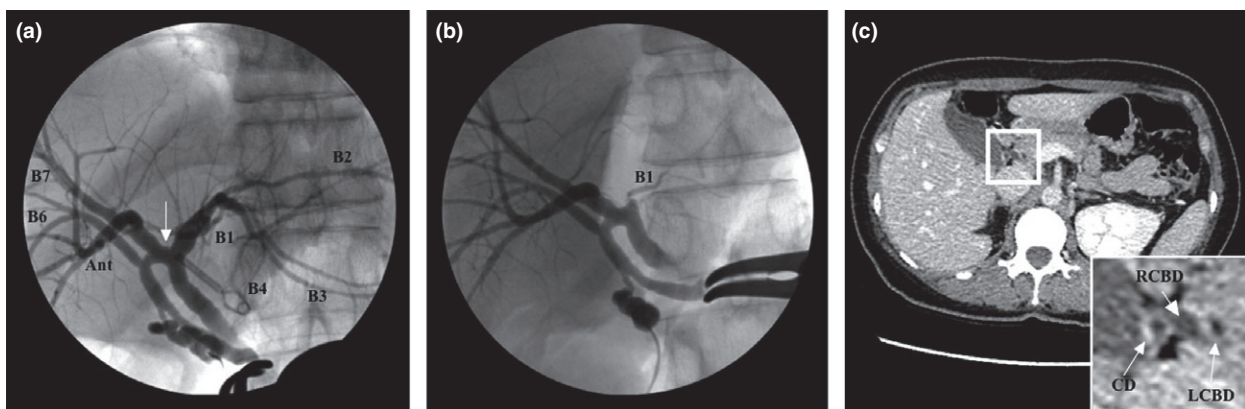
(a) An IOC image showing the single biliary drainage of DCBD with a proximal communicating channel (white arrow). The cystic bile duct is fused with the right common bile duct. (b) An IOC image demonstrating an optimal site of biliary transection (white arrow). (c) Preoperative computed tomography showing the cystic duct (CD), the right common bile duct (RCBD) and the left common bile duct (LCBD).
